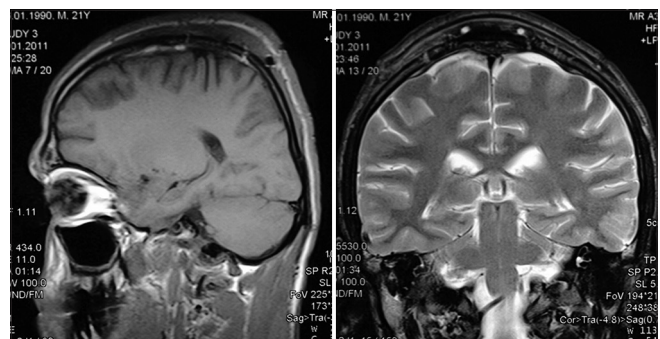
Postoperative MRI revealed that the epidural hematoma was completely evacuated
